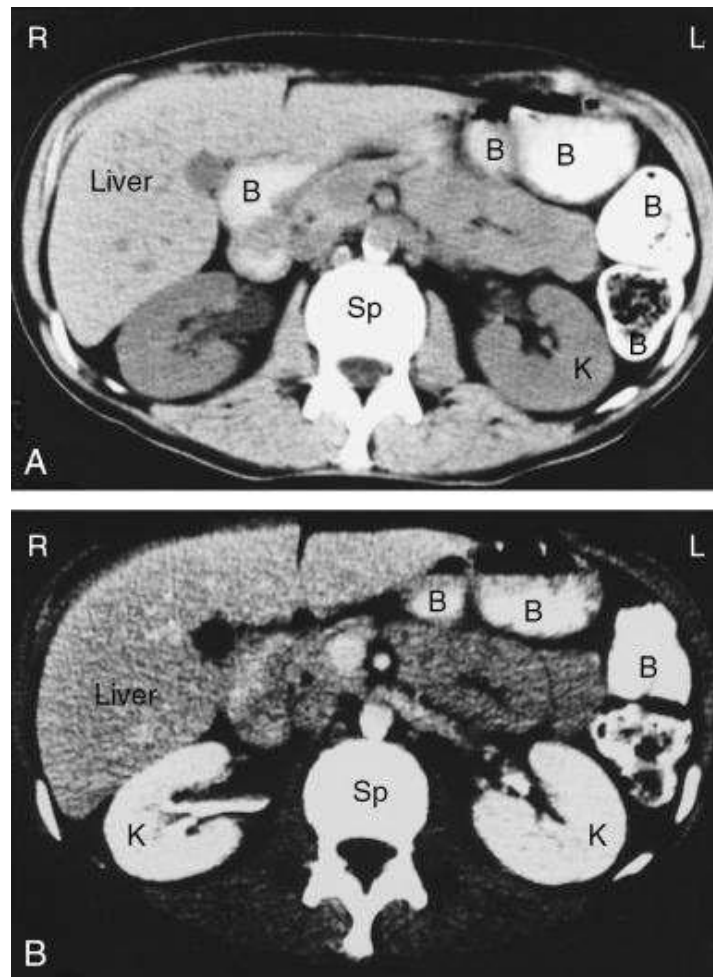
Computed tomography (CT). B = Bowel , K = Kidney
